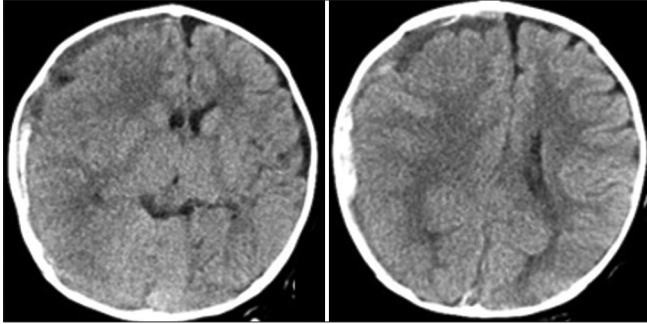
Computed tomography on admission revealed the right subdural hematoma with midline shift.
